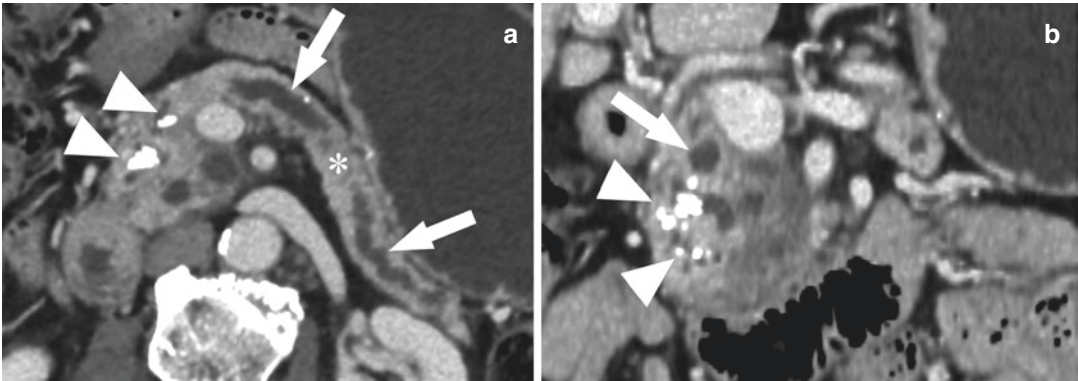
Advanced-stage chronic pancreatitis. (a) Axial contrast enhanced portal venous phase CT image and (b) coronal contrast enhanced portal venous phase CT image show markedly dilated and tortuous MPD (arrows)
